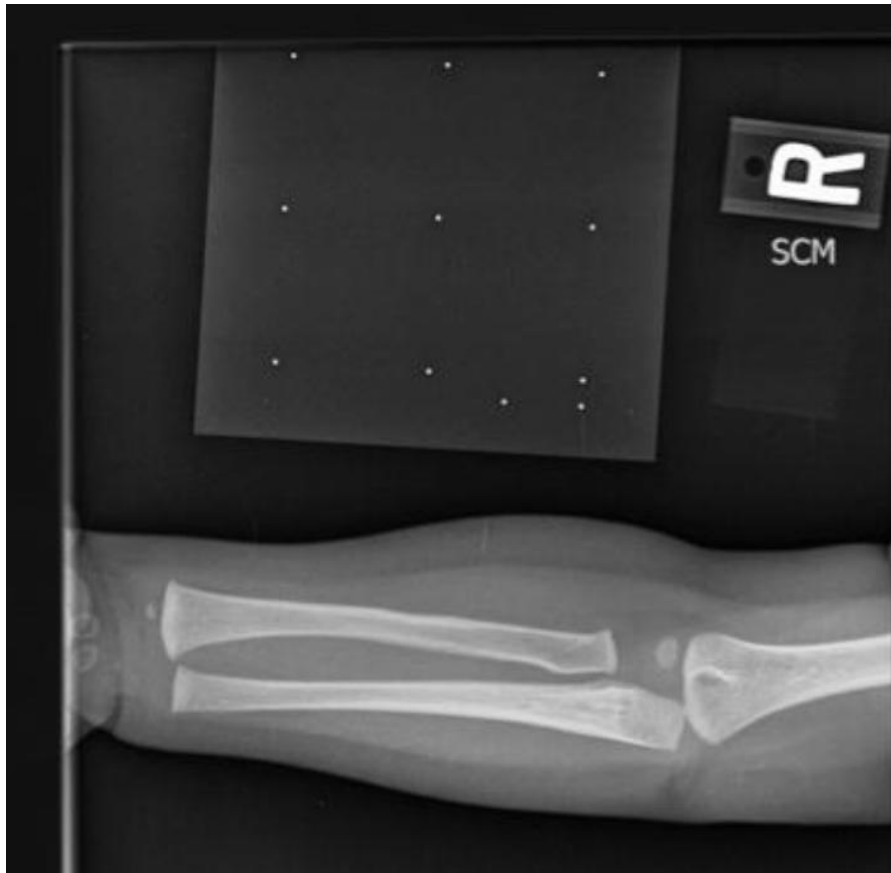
Radiograph image from a site that used the RRD.
